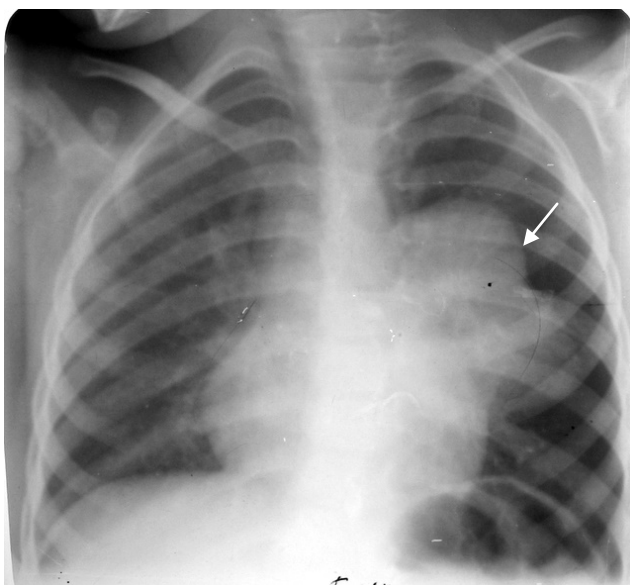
The frontal chest radiograph. At the left in the hilum a polycyclic shadow with accurate contours (arrow). Tuberculosis of intrachest lymph nodes of the left lung (tumoral form)
